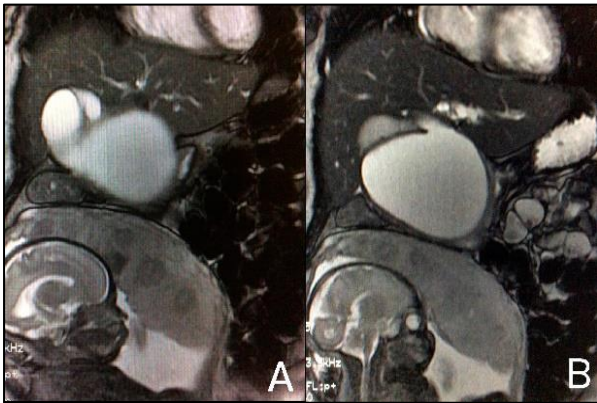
A) and B) Coronal view of magnetic resonance imaging showing the choledochal cyst and gravid uterus.
